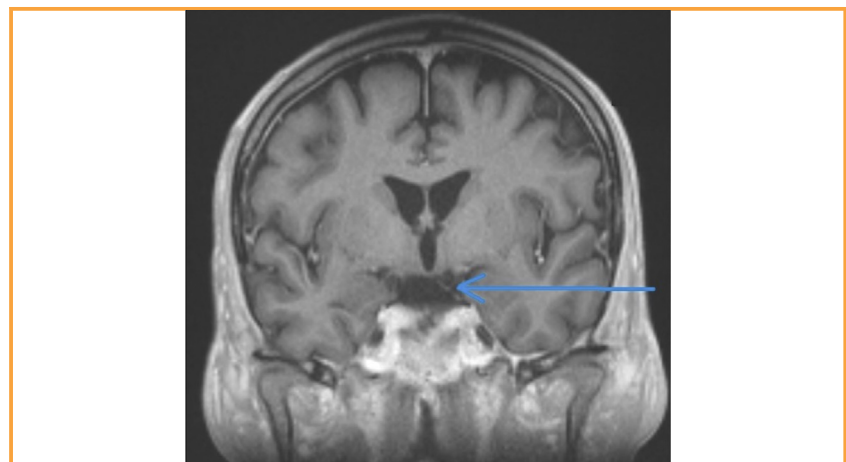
Coronal T1-weighted magnetic resonance imaging of the brain with contrast medium shows enhancement of left cranial nerve III (arrow).
